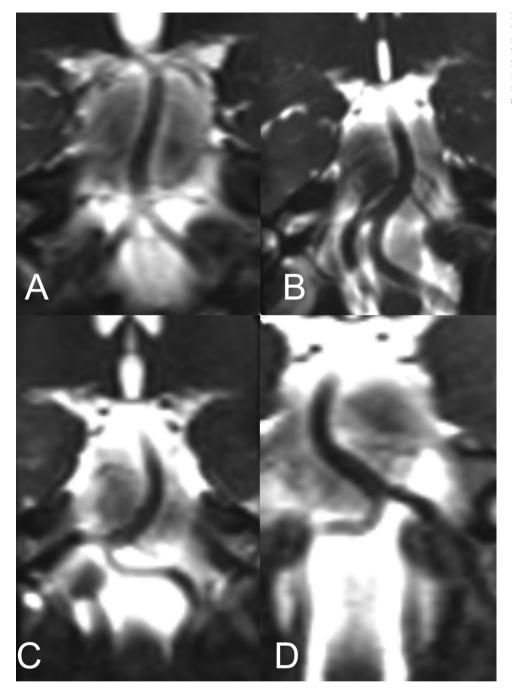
Coronal view MRI of the vertebrobasilar arteries in four patients suffering from MPS IVa A) normal course of the BA and VAs, B) tortuosity of both VAs in the V4 segment, "C"-shaped BA, C) kinking in the left vertebrobasilar transition, kinking in the left V4 segment, tortuosity in the left V4 segment, "C"-shaped BA, D) kinking in the right V4 segment, "C"-shaped BA BA.
